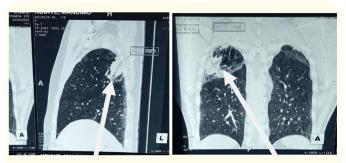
CT THORACIC: Right alveolar opacity and diffuse reticular.
